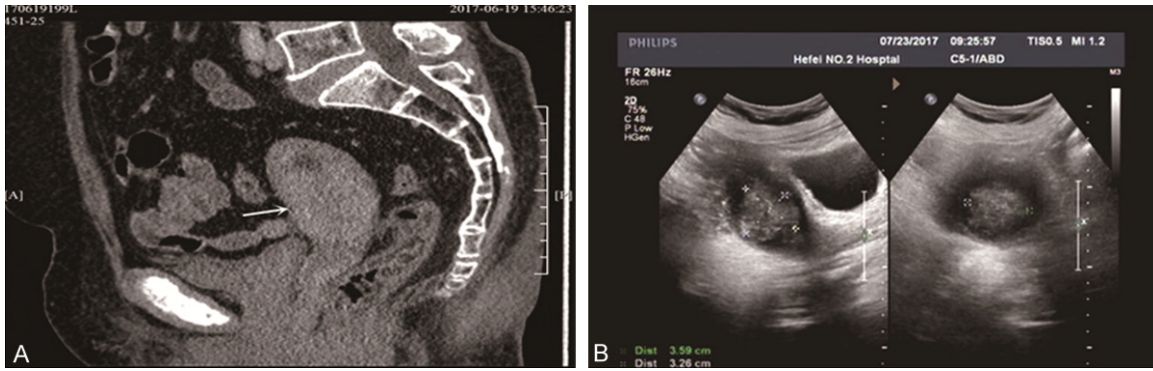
CT (A) and vaginal ultrasound (B) showed an area of accumulation in uterus (size 49*40*47 cm) with uterine cavity effusion.
